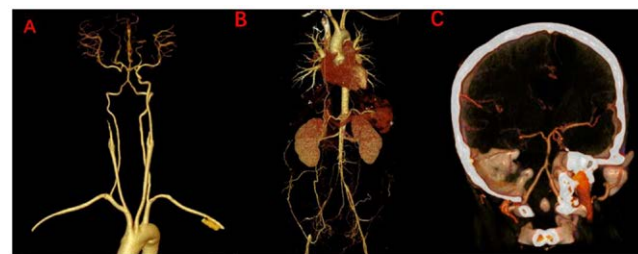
APS related Large Vessel Lesions in CT angiography and 3D Reconstruction
